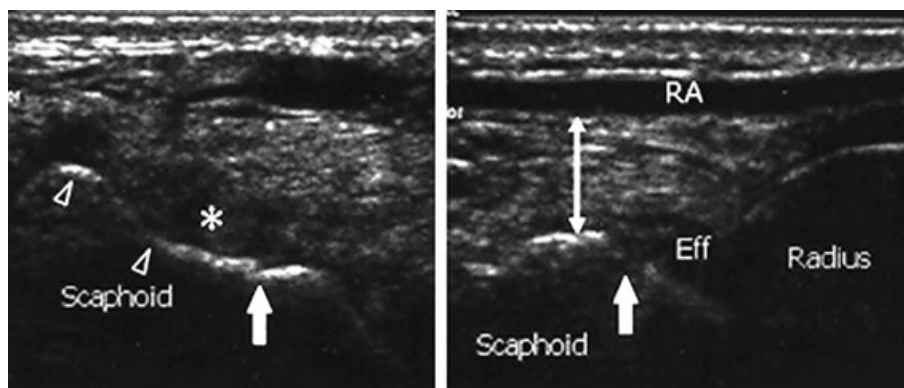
High-spatial resolution ultrasonography (HSRS) in the diagnosis of scaphoid fracture. Longitudinal ultrasound image shown (a) obtained over the palmar aspect of the wrist displaying the scaphoid cortex as a hyperechoic line (open arrowheads). An interruption of the cortex (arrow) corresponds to the fracture line. There is surrounding irregular hyperechoic hematoma (*). A longitudinal image attained over the lateral aspect of the same wrist (b) again shows an interruption of the cortex (arrow), and an effusion within the radiocarpal joint (Eff). There is thickening of the soft tissue (double arrow) with displacement of the radial artery (RA). (Permission Pending – Fusetti C, Poletti A, Pradel PH *et al.* *Diagnosis of occult scaphoid fracture with high spatial resolution sonography: a prospective blind study.* *J. Trauma.* 2005; 59: 677–81. fig. 2a,b).
